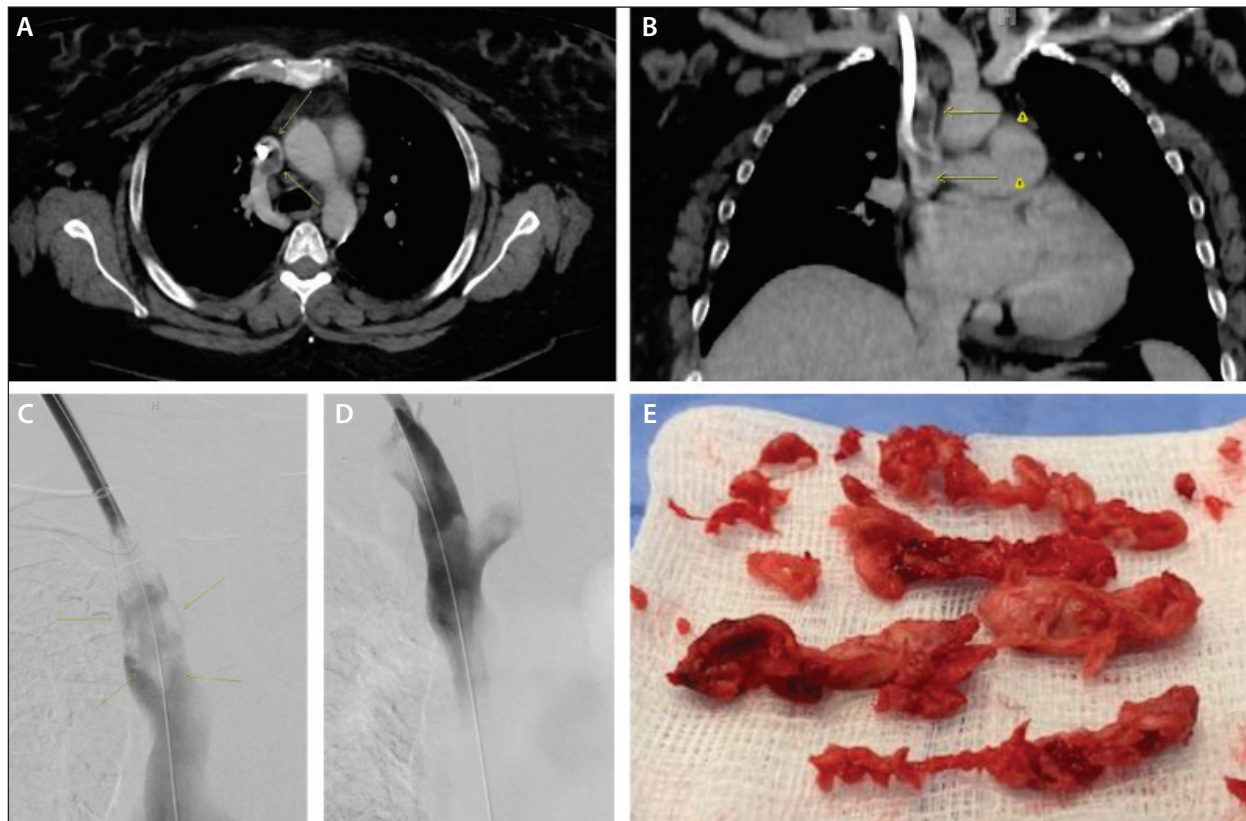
Axial contrast-enhanced chest CT images demonstrated nearly occlusive thrombus within the SVC around a 15.5-F dialysis catheter (A). Coronal contrast-enhanced chest CT images demonstrated nearly occlusive thrombus within the SVC around the dialysis catheter (B). Digital subtraction angiography performed before and during endovascular thrombectomy demonstrated thrombus within the SVC and at the cavoatrial junction; thrombus extended into the central left brachiocephalic vein as well (C). Digital subtraction angiography performed after endovascular thrombectomy demonstrated an approximately 75% decrease in clot burden within the SVC (D). Organized thrombus extracted with eight ClotTrievers passes (E).
